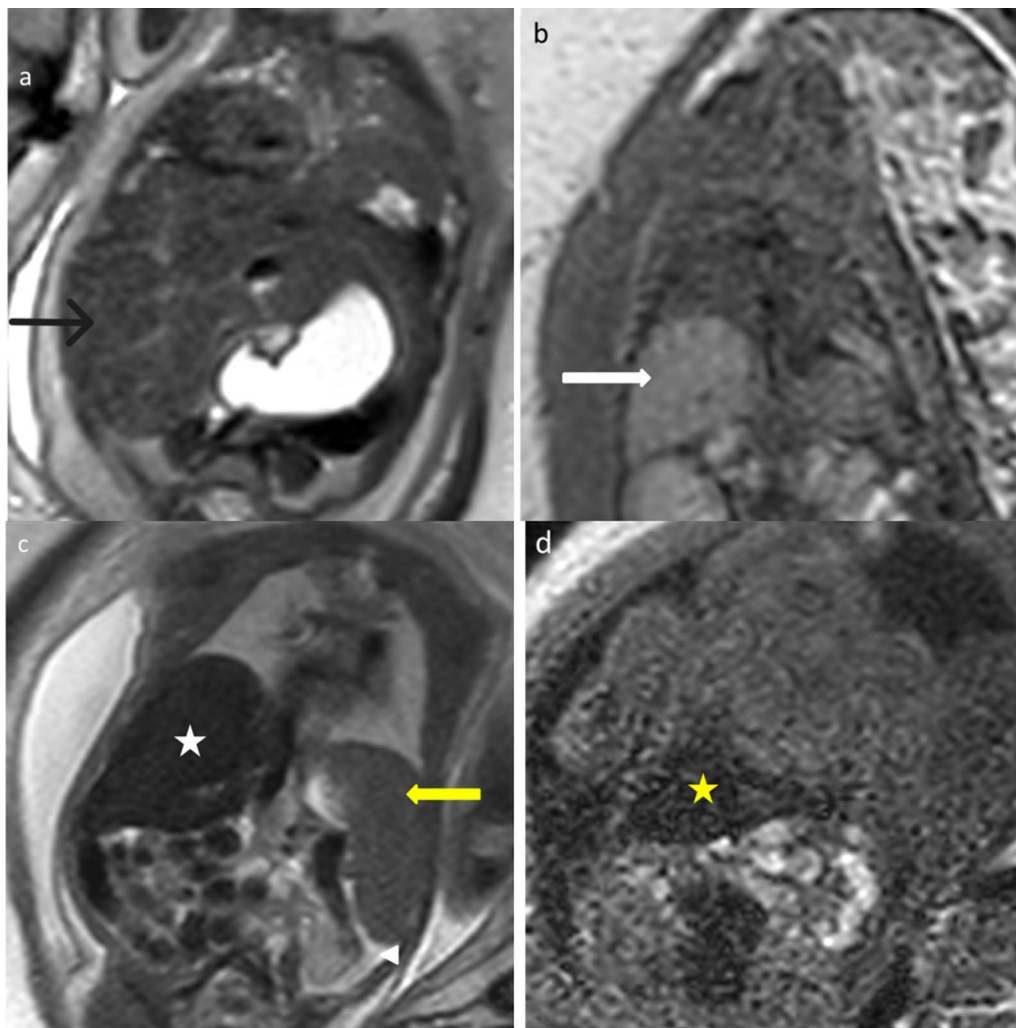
(a,b) Normal T2 and T1 weighted coronal images of fetal MRI (1.5 T) at the level of thorax and abdomen in third trimester show normal T2 hypointense signal (white arrow) and normal T1 hyperintense signal of liver (black arrow). (c,d) T2 and T1 weighted coronal sections of fetal MRI (1.5 T) in our case show intense T2 hypointense (white star) and T1 hypointense signal of liver (yellow star), splenomegaly (yellow arrow) and mild ascites (arrowhead)
